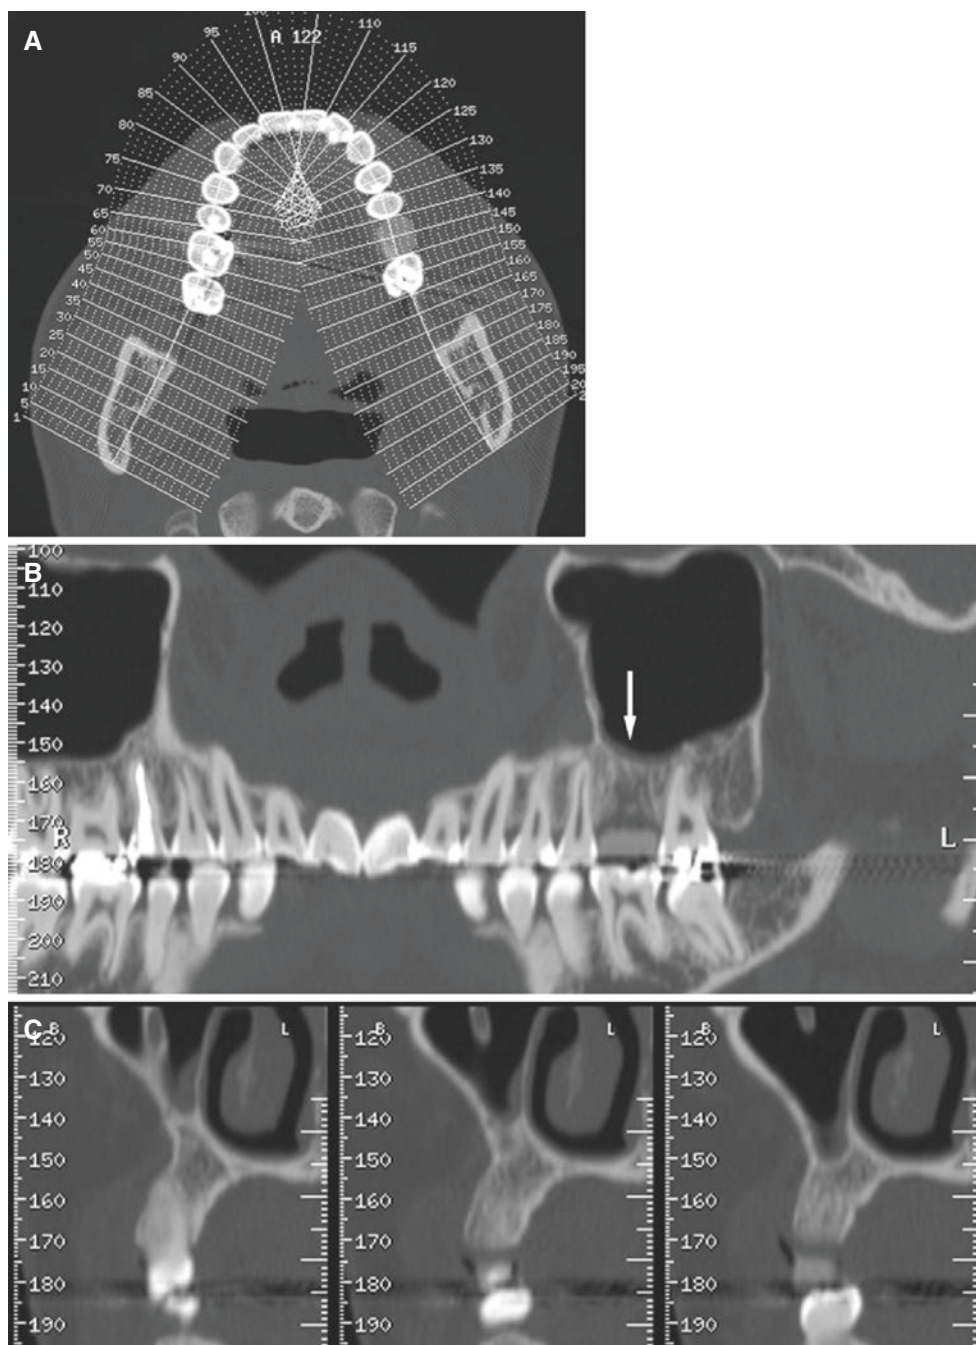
Alveolar process examination before and after dental implant surgery; one-tooth implant. (A) Axial CT image with DentaScan program, preoperative. (B) Panoramic and (C) cross-sectional images show edentulous area of alveolar process (*arrow*) with acceptable
